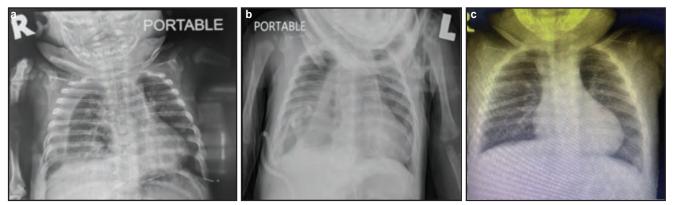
Chest radiographs of the patient. (a) Frontal supine radiograph shows loculated effusion (arrow) at the right upper and middle zone with right lower lobe collapse evidenced by tenting of the right hemidiaphragm and lower zone opacity). Bilateral air space opacities (including retrocardiac region) suggesting active lung infection. (b) Follow-up chest radiograph showed persistent right loculated effusion with right lower lobe collapse, complicated with pneumothorax. Drainage catheter tip at the area of effusion. (c) Radiograph during review three weeks later in the clinic which showed complete resolution of effusion and lower lobe collapse with no new active lesion seen
